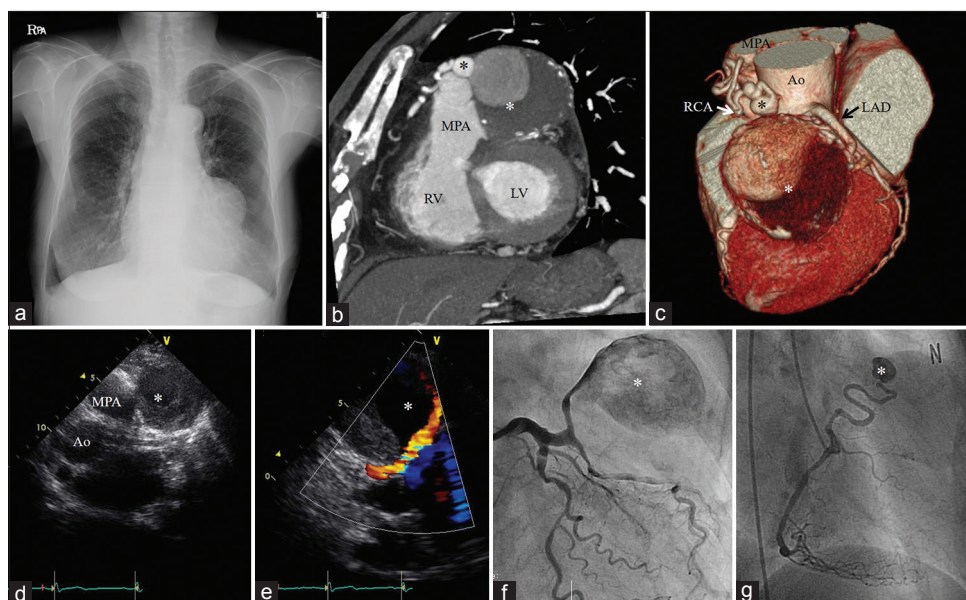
CAF with a giant saccular aneurysm. (a) Chest radiography showed mediastinal mass on the left cardiac border. (b and c) The cardiac computed tomography showed CAFs from proximal LAD artery with huge aneurysmal dilatation and from the proximal RCA. (d and e) Echocardiography showed huge CAF had systolic shunt flow, suggesting a connection with MPA. (f and g) Coronary angiography confirmed the CAFs originated from the first diagonal branch and the proximal RCA. *Aneurysm; LV: Left ventricle; RV: Right ventricle; Ao: Aorta; CAFs: Coronary artery fistulas; LAD: Left anterior descending; RCA: Right coronary artery; MPA: Main pulmonary artery.
